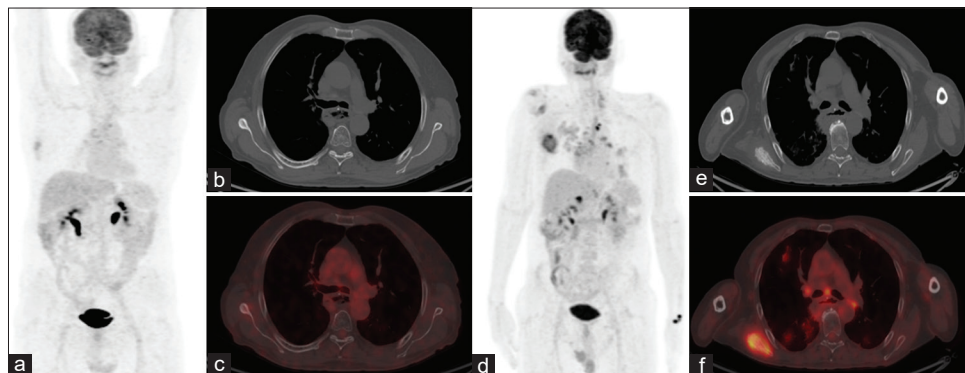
Case of 65-year-old male who underwent chemo-and radio-therapy for squamous cell carcinoma of the esophagus. The patient underwent surveillance FDG positron emission tomography/computed tomography (a [MIP], b [Axial computed tomography] and c [Axial Positron emission tomography/computed tomography]) 3 months after treatment, which showed no significant metabolically active residual disease at the site of the primary. However, an area with mildly increased radiotracer uptake was noted in relation to the lateral border of the scapula, with minimal sclerosis in the corresponding computed tomography images (a-c). Follow-up FDG Positron emission tomography/computed tomography (at 6 months from baseline) revealed progressive disease involving the right scapula (d [MIP], e [Axial computed tomography] and f [Axial Positron emission tomography/computed tomography]). Also note the areas of increased uptake in the both lungs and mediastinal lymph nodes, which were infective in origin. This case shows the sensitivity of Positron emission tomography/computed tomography in detection of even minimal residual disease (a-c), which might have otherwise been missed in computed tomography (due to minimal structural changes)
